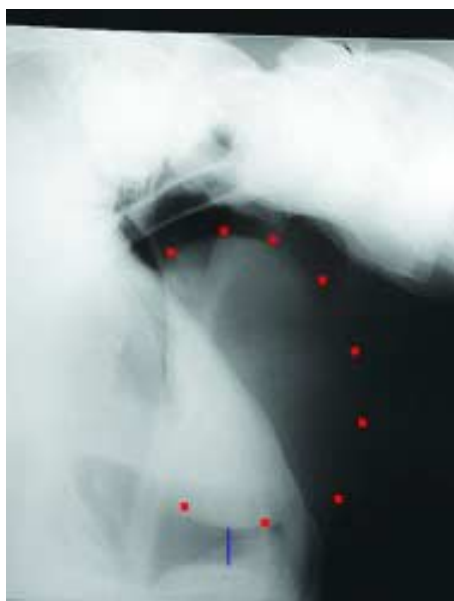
Standing lateral radiograph of pharynx, larynx and guttural pouches showing a large soft tissue mass within a guttural pouch (red markers). There is marked soft tissue thickening between the guttural pouches and pharynx and considerable ventral deviation of the dorsal pharynx (blue line).
